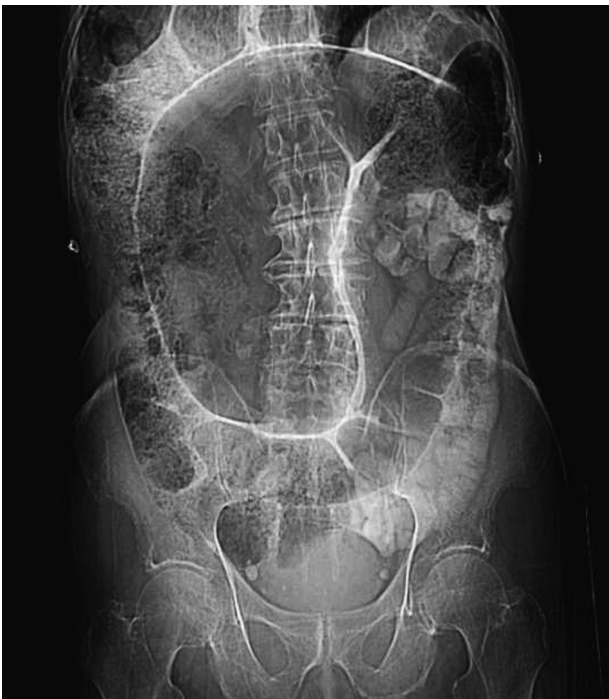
Plain radiographic image of abdomen showing the markedly distended ahaustral sigmoid loop arising from the left lower quadrant and extending towards the diaphragm, a “coffee bean” or “bent inner tube” sign.
